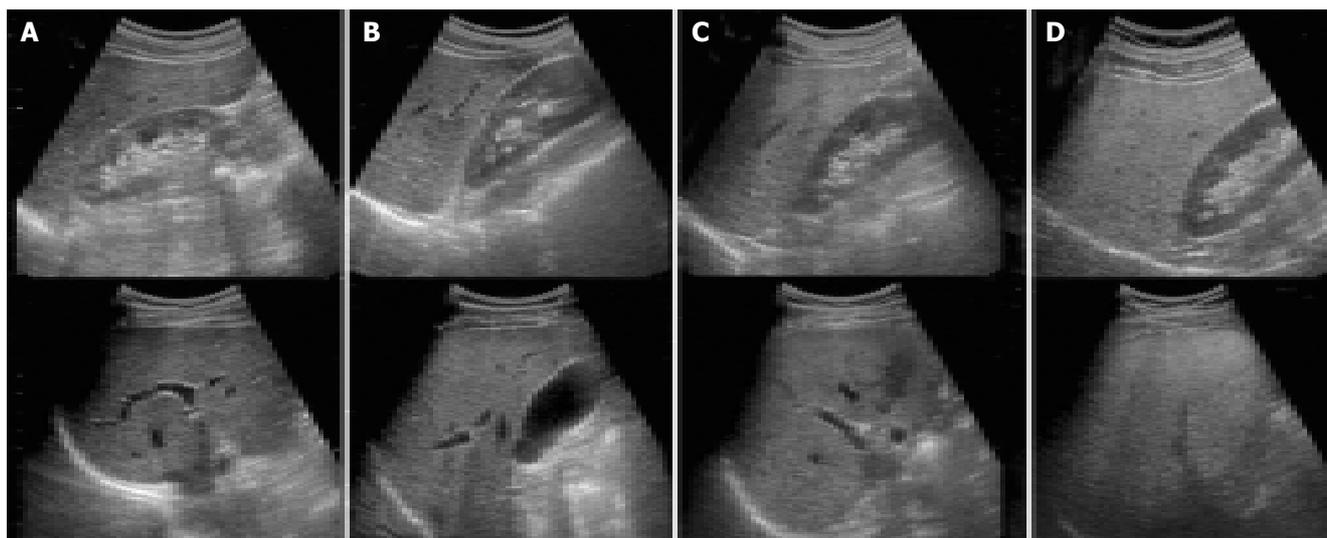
Ultrasonographic findings of liver according to the degree of steatosis. (A) Normal liver, (B) mild steatosis: a slight augmentation in liver echogenicity, a slight exaggeration of echogenic discrepancy between liver and kidney, and a relative preservation of echo line in the portal vein wall. (C) Moderate steatosis: a loss of echo line in the portal vein wall, particularly from the peripheral branches, resulting in a featureless appearance of the liver. (D) Severe steatosis: much greater reduction in echo penetration, a loss of echogenicity in most of the portal vein wall, including the main branches, and a large echo discrepancy between liver and kidney. Adapted from Saverymuttu *et al.*^[17].
